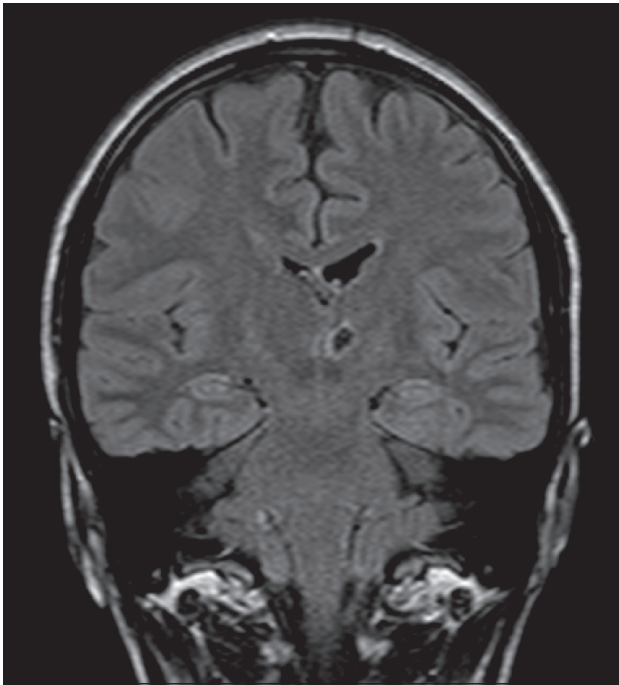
Preoperative MRI showing a left-sided thalamic infarction. Hippocampal sclerosis or other possible epileptogenic lesions were not identified.
